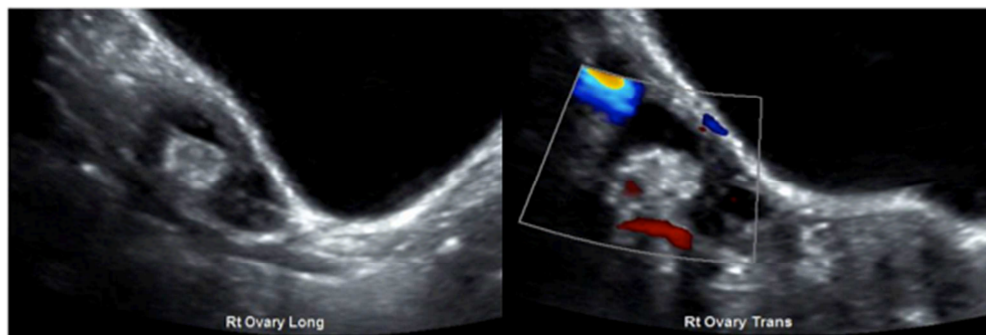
Images from abdominal ultrasound showing complex, right ovarian cyst consistent with an ovarian dermoid.
